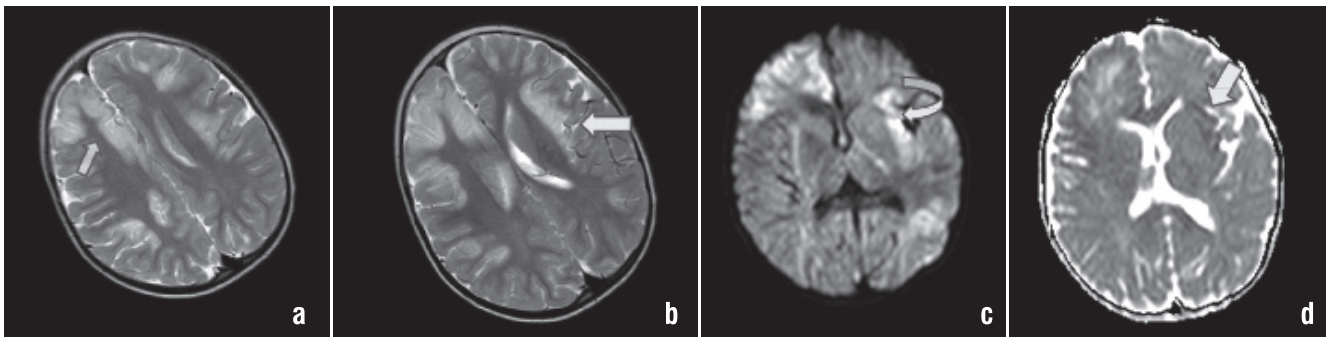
a, b) Axial FLAIR images [TR (repetition time)/TE (echo time); 3000/100 ms] show bilateral lesions of insulae, frontal lobes and cingulate gyrus. c, d) images and axial isotropic trace diffusion images (TR/TE; 6600/89 ms with a maximum b value of 1000 s/mm²) reveal restricted diffusion pattern corresponding apparent diffusion coefficient maps reveal low values in the lesions
